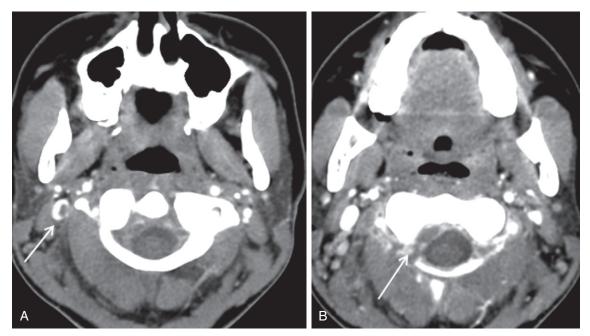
Patient, presenting with neck pain, *Fusobacterium necrophorum*–induced sepsis. A, Contrast-enhanced axial CT through the upper neck delineates a clot (*arrow*) in the right jugular vein. B, Axial contrast-enhanced image just below delineates right anterior rim, enhancing epidural fluid collection. The diagnosis was Lemierre disease with epidural abscess.
